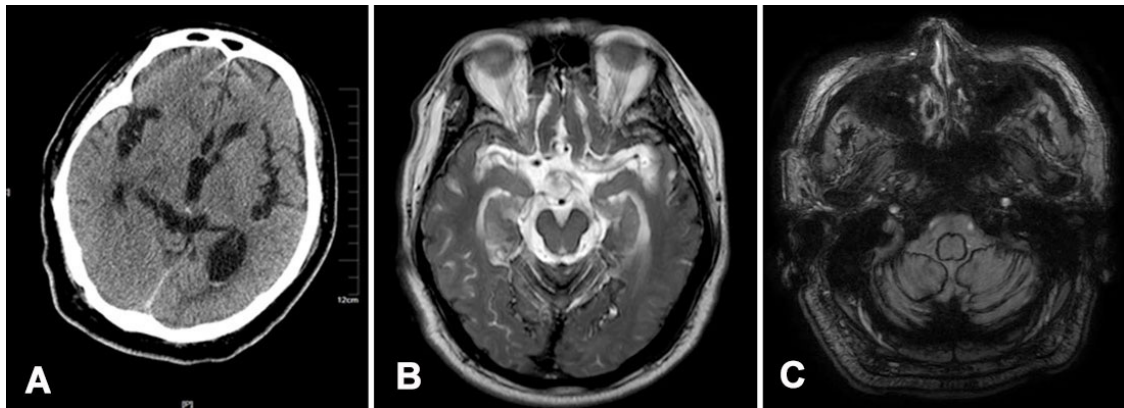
(A) Computed tomography scan showed that there was some blood in the posterior horn of the lateral ventricle; (B) T2-WI showing linear hypointensities along the surfaces of the brainstem and cerebellum; (C) susceptibility weighted imaging showing a dark rim around the cerebellar lobes and midbrain brain, corresponding to hemosiderin deposition
